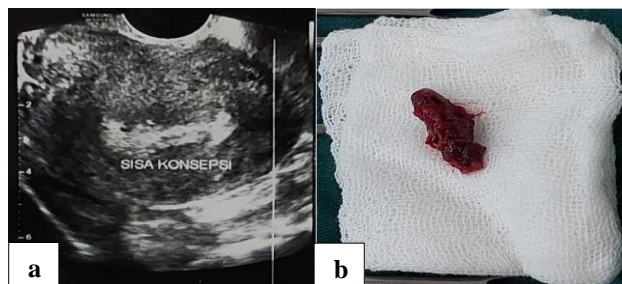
(a) Ultrasound image of intrauterine hypohyperechoic, and (b) post curettage conception remains.
